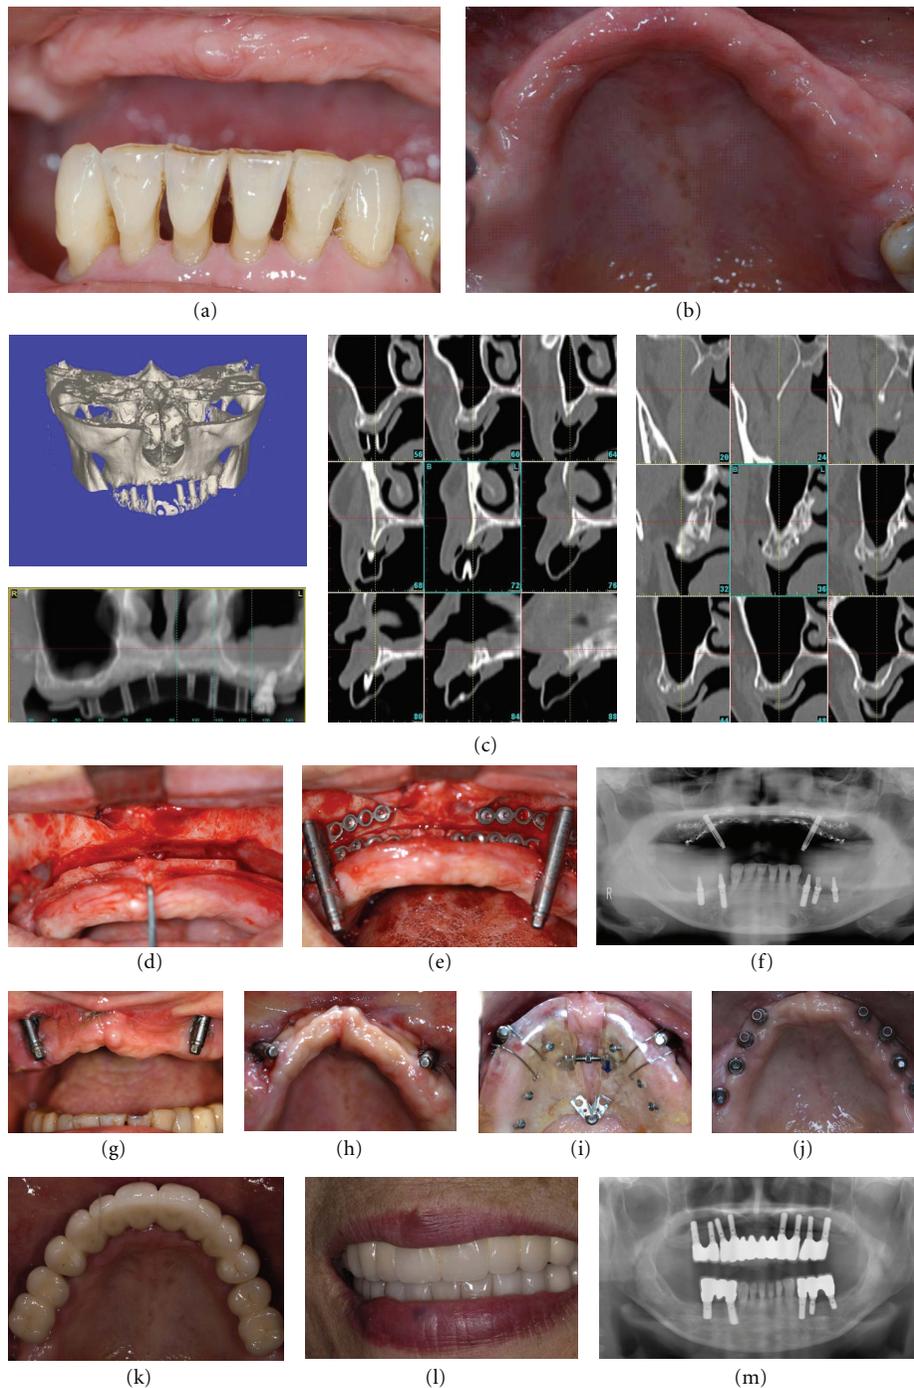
Representative case of bilateral sinus lifting and simultaneous total alveolar distraction for an edentulous severely atrophic maxilla (Case 2, Table 1). (a, b) Preoperative intraoral views; (c) preoperative CT views; (d) intraoperative view. After the end of the bilateral sinus floor elevation and completion of the total alveolar osteotomy: (e) sufficient sinus lifting with an equal-volume mixture of particulate autogenous cancellous bone/ β -TCP was observed and the bilateral alveolar distractors were set; (f) postoperative panoramic X-ray; (g) after the end of vertical distraction; (h) good vertical distraction was obtained, but the maxillary alveolar arch was very narrow and V-shaped; (i) bilateral alveolar segmental widening with distraction was followed with use of an orthodontic palatal expansion device (the Hyrax device); (j) implant placement at ideal positioning was obtained for dental implant-anchored fixed prosthetic rehabilitation; (k, l) the definite prosthesis was set after 2 years with a provisional restoration during the postloading period for total oral rehabilitation; (m) panoramic X-ray taken 3 years later.
